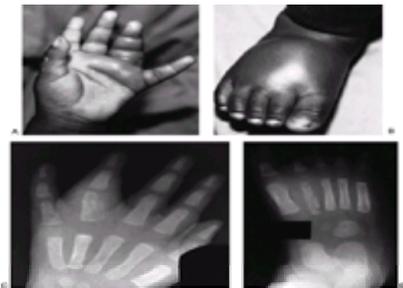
Osteomyelitis in a 7-month-old boy with sickle cell anemia. Patient presented with swelling of the hand and foot. Initial diagnosis was dactylitis. Because of persistent swelling and elevated temperature, aspiration was performed 48 h after admission. Purulent material was obtained, and cultures demonstrated *Salmonella* organisms. Antibiotic therapy, and surgical drainage of the hand and foot, successfully resolved the infection. A: Forty-eight h after admission, the hand shows marked swelling in the region of the ring finger. B: Forty-eight h after admission, there is swelling on the dorsum of the foot. C: Anteroposterior radiograph of the hand on the 15th hospital day. D: Anteroposterior radiograph of the foot on the 15th hospital day. Osteolysis and periosteal elevation are noted in the proximal phalanx of the ring finger and the second metatarsal. Although this patient had osteomyelitis, the radiographic appearance also is consistent with a healing dactylitis. (From ref. 62, with permission.)
